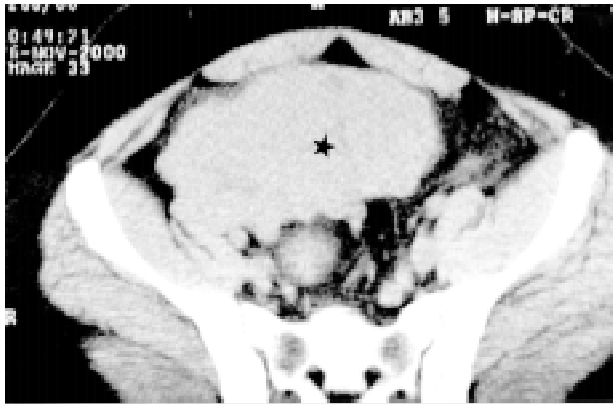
Computed tomography demonstrating an irregular solid pelvic mass (asterisk).
